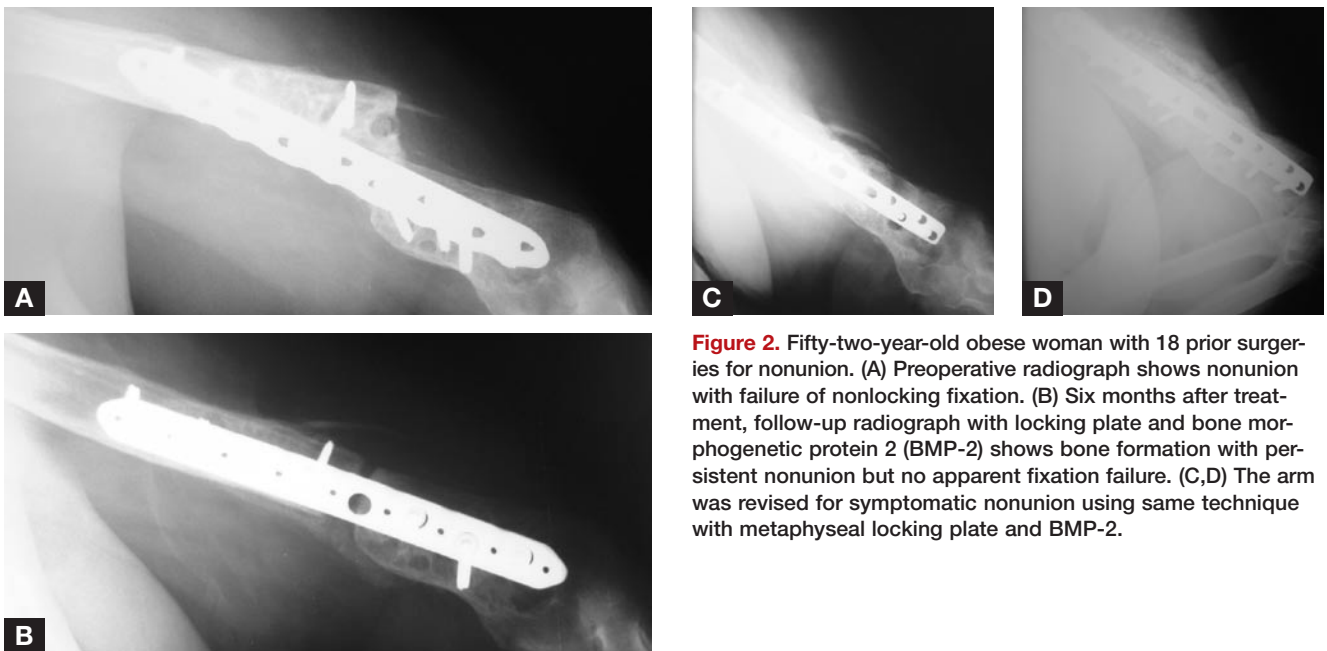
Fifty-two-year-old obese woman with 18 prior surgeries for nonunion. (A) Preoperative radiograph shows nonunion with failure of nonlocking fixation. (B) Six months after treatment with locking plate and bone morphogenetic protein 2 (BMP-2) shows bone formation with persistent nonunion but no apparent fixation failure. (C,D) The arm was revised for symptomatic nonunion using same technique with metaphyseal locking plate and BMP-2.
